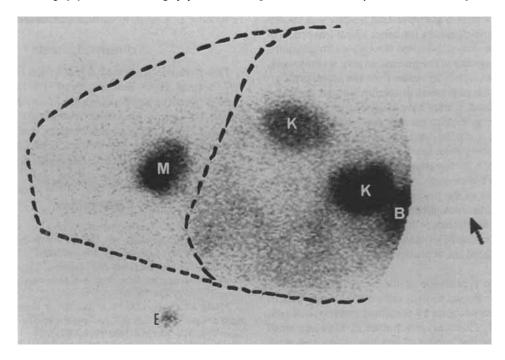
Right lateral scintigram 7 months after surgery. Chest and abdomen 4 hours after injection of ""indium-labeled pentetreotide (OctreoScan). M, left atrial mass; K, kidney; B, bladder; E, extrathoracic radioactive marker positioned near the left cardiac apex. Dotted lines indicate the thorax and diaphragm.
